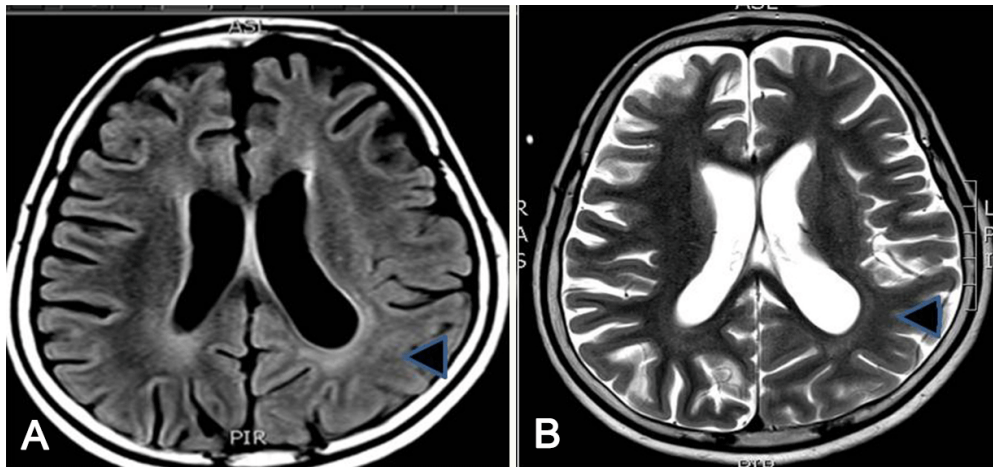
(A) FLAIR axial image; (B) T2-Weighted axial image. FLAIR and T2W axial MRI sequences in case 2 demonstrating global atrophy with loss of grey white matter differentiation over the left posterior quadrant. This was done 1 month after the first episode of complex partial status epilepticus. FLAIR: fluid attenuated inversion recovery; T2W: T2-weighted; MRI: magnetic resonance imaging
